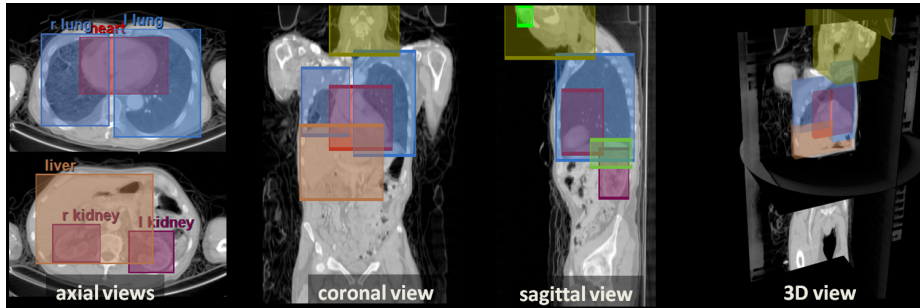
Constructing labelled ground-truth databases. Organs within 3D CT scans are labelled via 3D, axis-aligned bounding boxes; different colours indicating different organs. Note that the fact that the boxes overlap is not a problem as they are used to indicate the position of the organ centre and the organ’s approximate extent.
